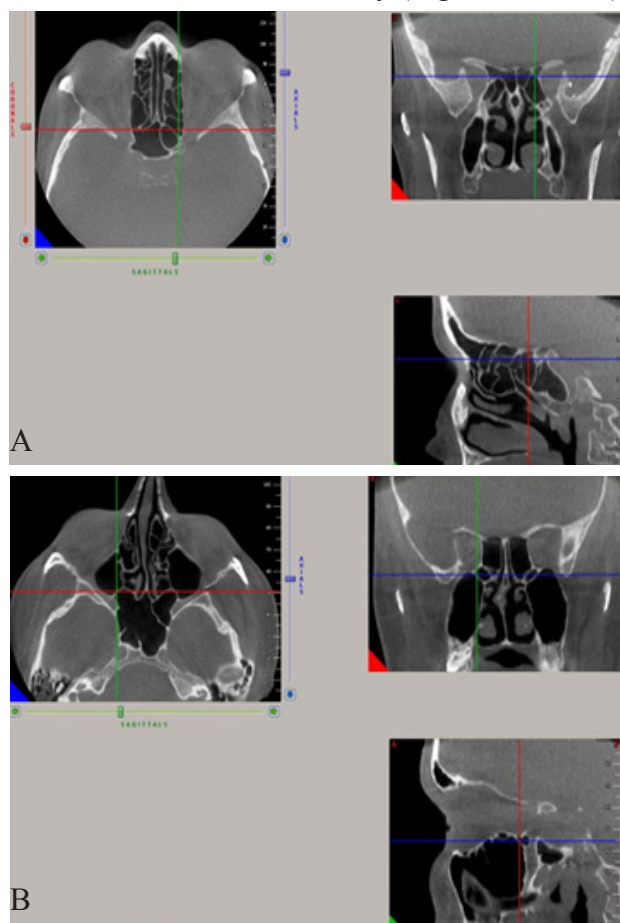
A) Onodi cell; B) Sphenomaxillary plate in reconstructed multiplanar CBCT images
